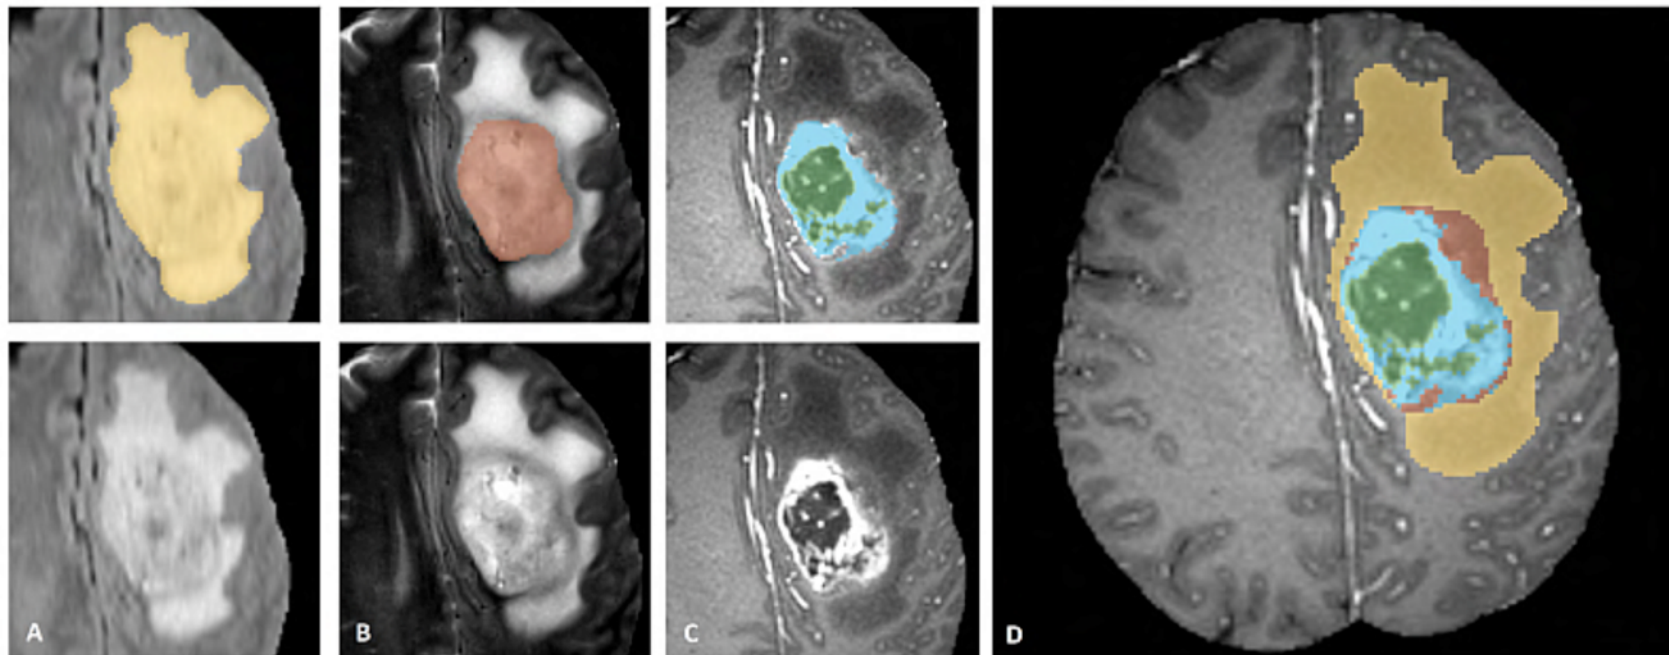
Glioma sub-regions. Shown are image patches with the tumor sub-regions that are annotated in the different modalities (top left) and the final labels for the whole dataset (right). The image patches show from left to right: the whole tumor (yellow) visible in T2-FLAIR (Fig.A), the tumor core (red) visible in T2 (Fig.B), the enhancing tumor structures (light blue) visible in T1Gd, surrounding the cystic/necrotic components of the core (green) (Fig. C). The segmentations are combined to generate the final labels of the tumor sub-regions (Fig.D): edema (yellow), non-enhancing solid core (red), necrotic/cystic core (green), enhancing core (blue). (Figure taken from the [BraTS IEEE TMI paper.](#))
